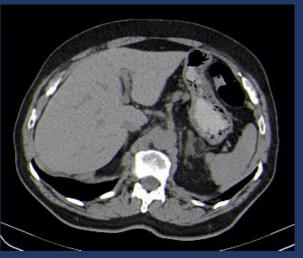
Left adrenal myelolipoma. Axial non-enhanced CT reconstrutions showing a well circumscribed fatty lesions on the left adrenal gland.
